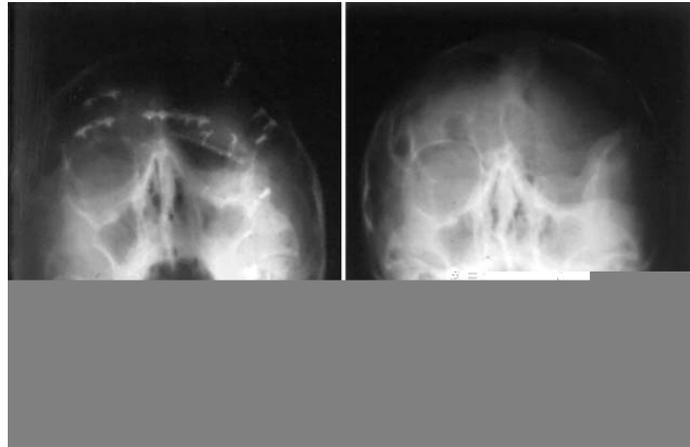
Pre- and post-operative X-ray.
